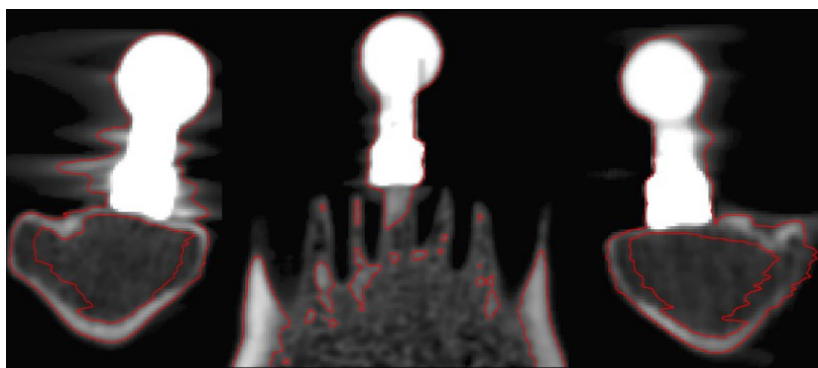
Segmented anatomical model from different points of view (top), below – the surfaces of the segmented anatomical model and the reference balls in CBCT images (bottom)
